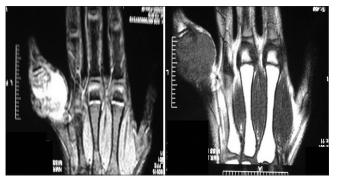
Magnetic resonance imaging in T1 and T2/soft tissue inflammatory response sequences showing the extent of the lesion in the little finger
